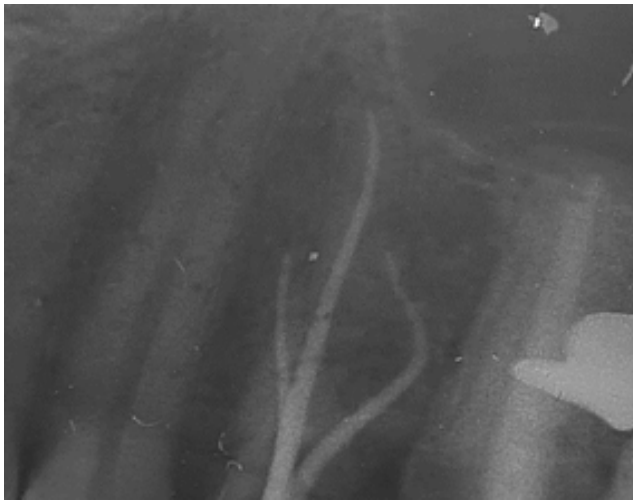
Radiograph confirmation of master cone for 24.
